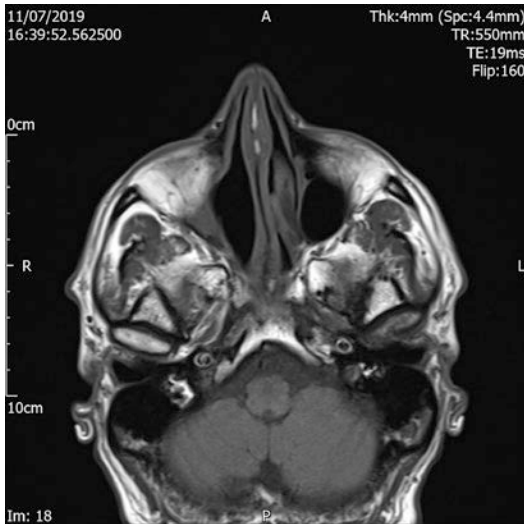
A 2 year post-treatment axial T2-weighted MRI scan demonstrating complete resolution of the sino-nasal cancer in both nasal cavities
